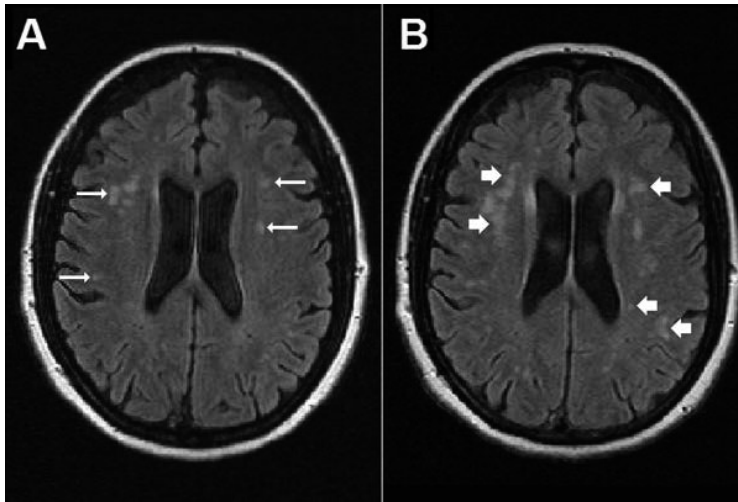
Example of deep white matter intensities at a similar level on FLAIR images of one participant showing DWMHs at baseline (A, long thin arrows) and progressive and new DWMHs at follow-up (B, short thick arrows)
